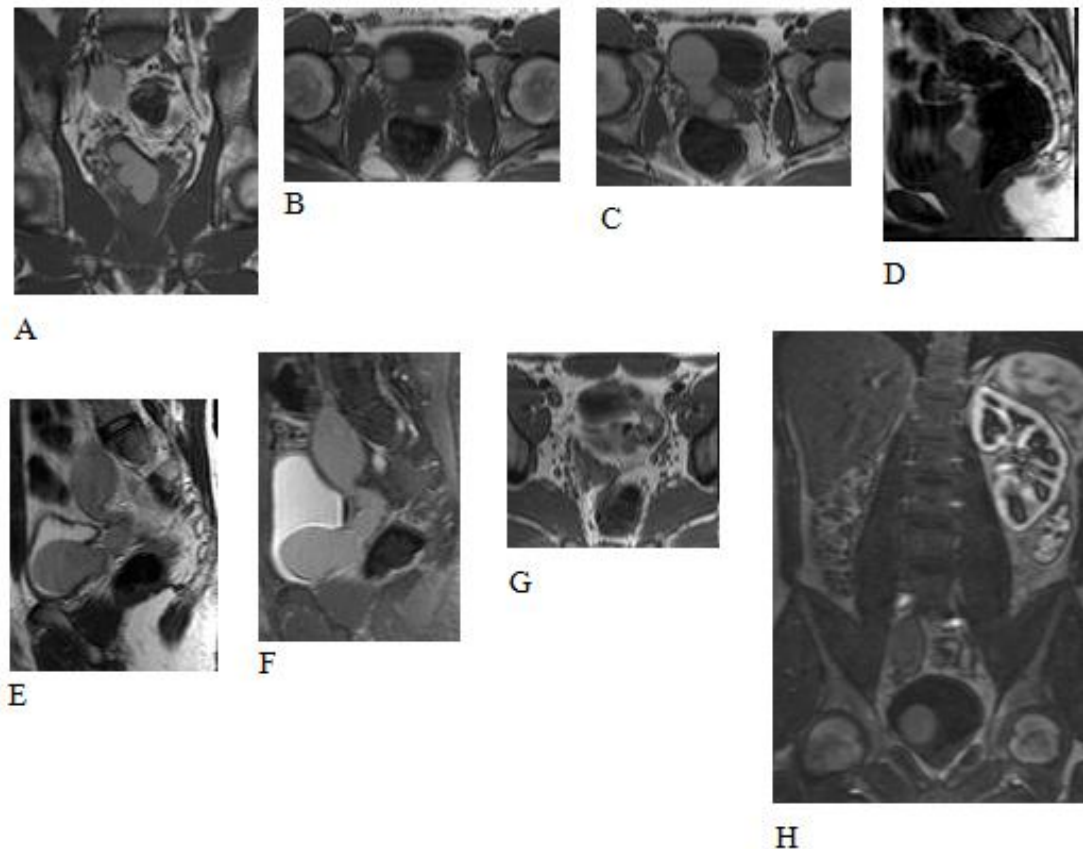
Pelvic MRI shows a multiloculated, tubular, complex cystic mass in the right pelvis compressing the bladder posteriorly. It originated from the midline, high above the base of the prostate. It was hyperintense on T1 (A-D) and T2 (E) weighted images indicating mucinous material or hemorrhage. The cyst did not show any contrast enhancement (F). The right seminal vesicle was displaced by the mass superiorly (G). The right kidney was agenetic and the left kidney was hypertrophic seen on postcontrast fat saturated T1 weighted image (H).
